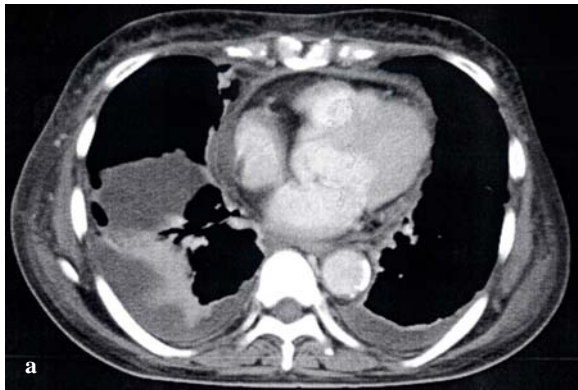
Enhanced chest computed tomography (CT) showed bilateral pleural effusions with atelectasis in the lower right lung field and pericardial effusion at the time of admission, b) Chest CT showed no interstitial opacity.
